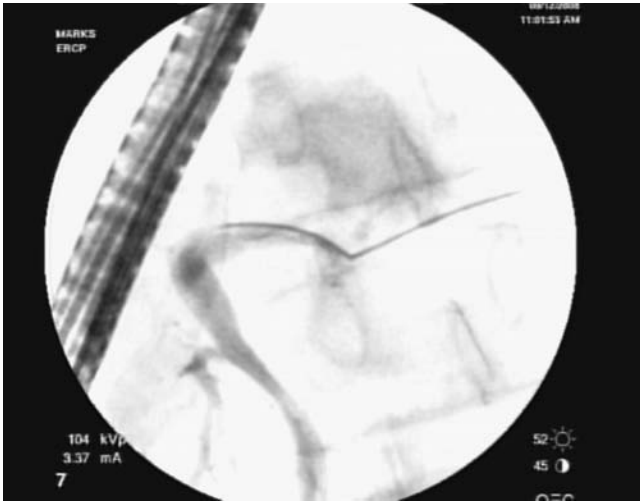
Radiographic image of a pancreatic duct wire prior to stent placement.
